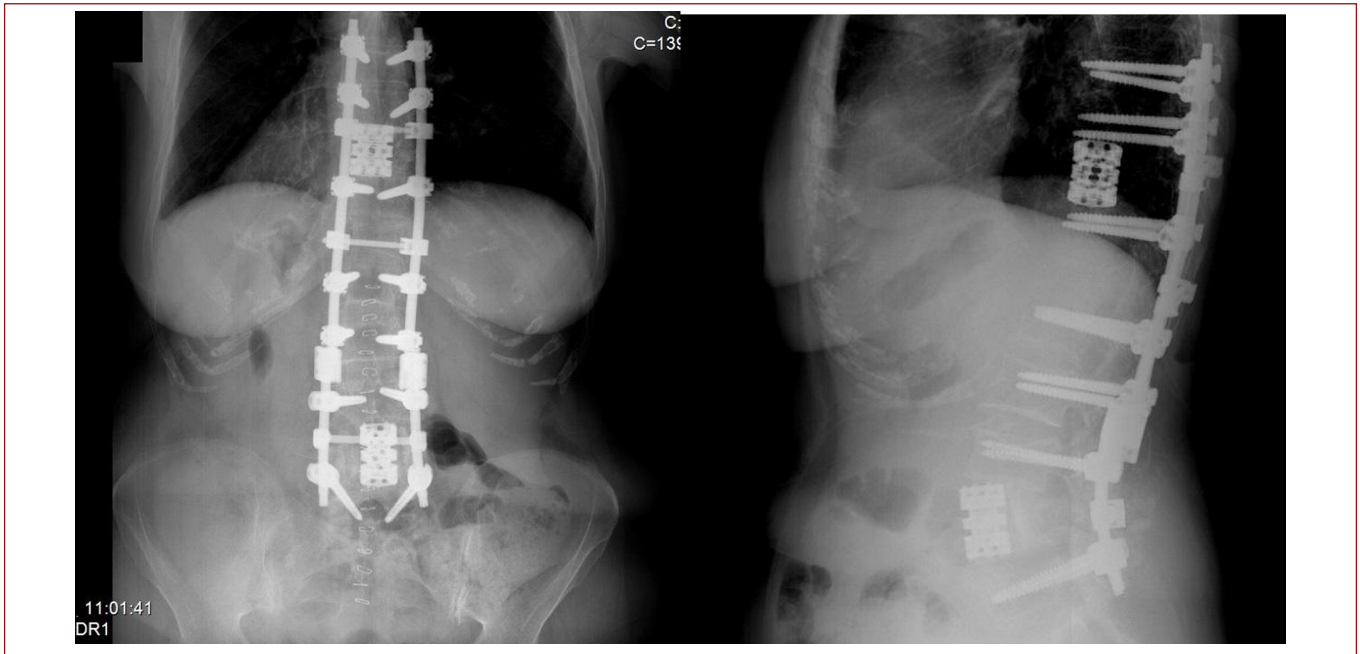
a) AP and b) lateral X-rays after PVCR at the L4 vertebra.
